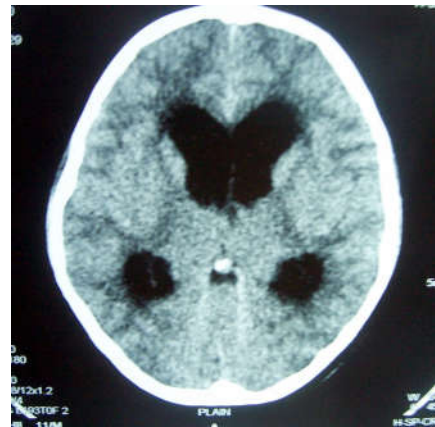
CT scan showing cerebral oedema and hydrocephalus. Fourth ventricle is normal.
